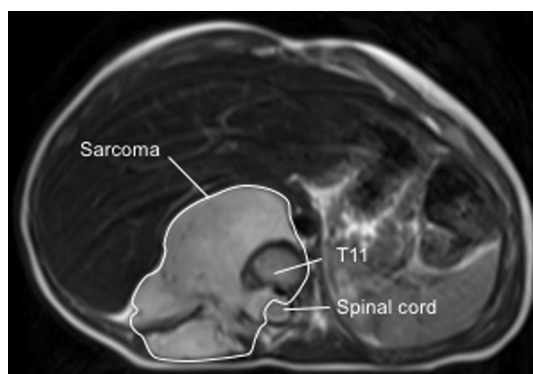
Preoperative MRI section showing the sarcoma and T11
